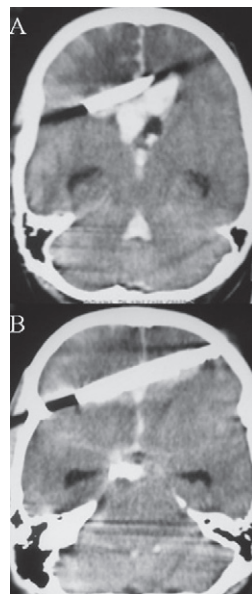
CT scan brain showing foreign body with the extensive parenchymal injury with contusion, and intraventricular bleed.
